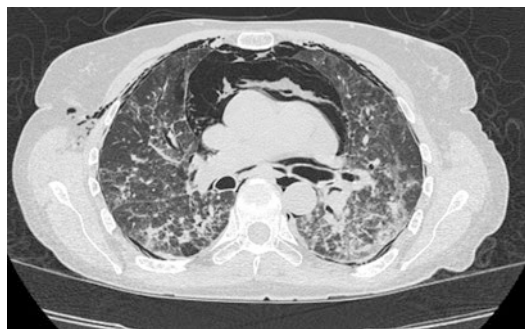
CT image of a patient with pulmonary fibrosis following HSCT showing pneumomediastinum, small bilateral pneumothoraces, and subcutaneous emphysema consistent with thoracic air-leak syndrome
